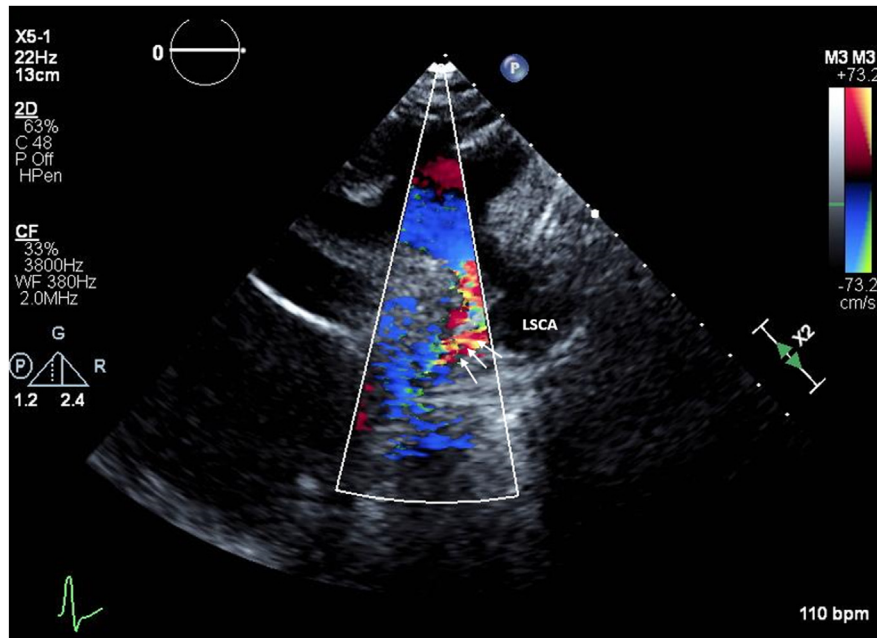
Two-dimensional TTE, suprasternal long-axis view with color-flow Doppler, demonstrates aliasing (*arrows*) and lack of antegrade flow across aortic isthmus. LSCA, Left subclavian artery.
